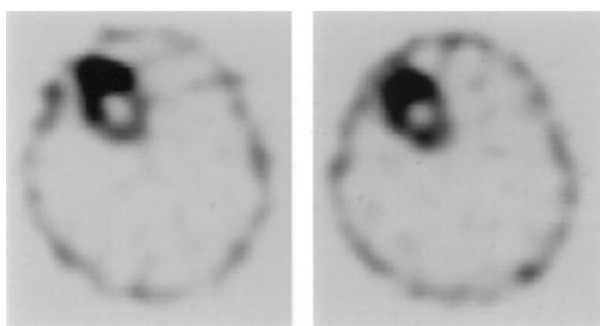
Tl-201 early (*left image*) and late (*right image*) brain SPECT in a 63-year-old woman with glioblastoma multiforme, 5.5 cm in diameter. The early uptake ratio (ER), the late uptake ratio (LR) and the ratio of LR to ER were 4.20, 3.27 and 0.78, respectively.
